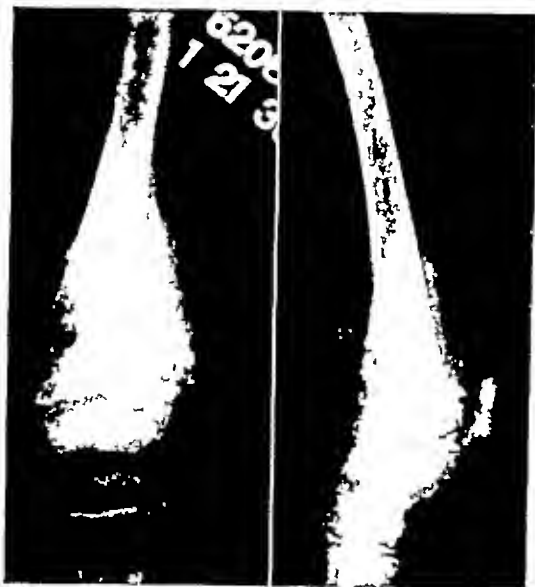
Roentgenogram taken on Jan 17 1936 Mottling of the lower end of the femur with an area of bone destruction is present There is marked periosteal reaction with new bone laid down irregularly in soft tissue
